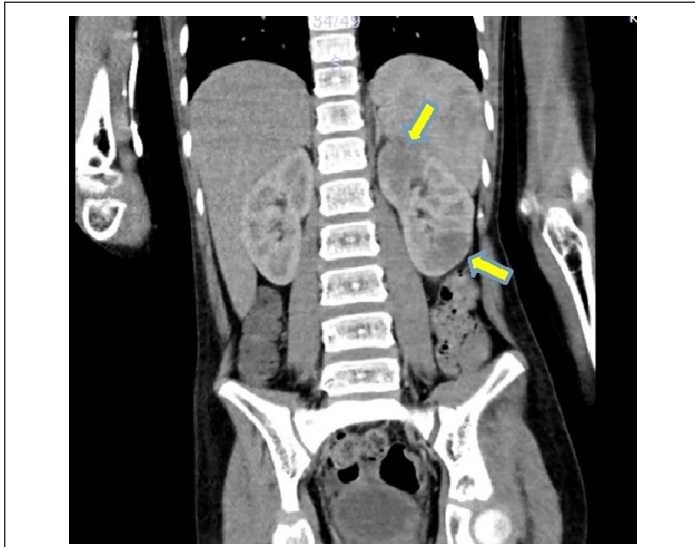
Hypodense patchy areas compatible with acute focal bacterial nephritis in the upper and lower poles of the left kidney in contrast-enhanced abdomen computed tomography.
